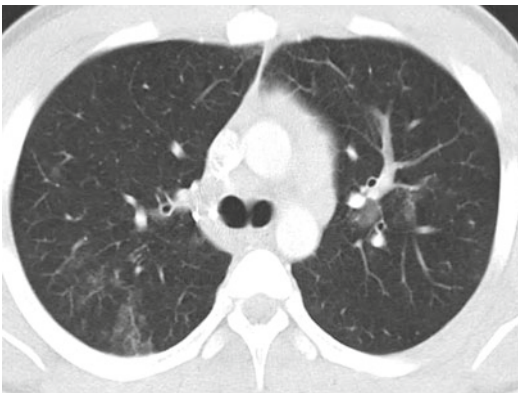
Chronic eosinophilic pneumonia after cyclophosphamide therapy. This 29-year-old man presented with a nonproductive cough after his second cycle of cyclophosphamide therapy and received a CT examination after an abnormal chest radiograph. CT showed upper lobe predominant ground glass opacities. On bronchoscopic biopsy, findings were in keeping with chronic eosinophilic pneumonia and organizing pneumonia
